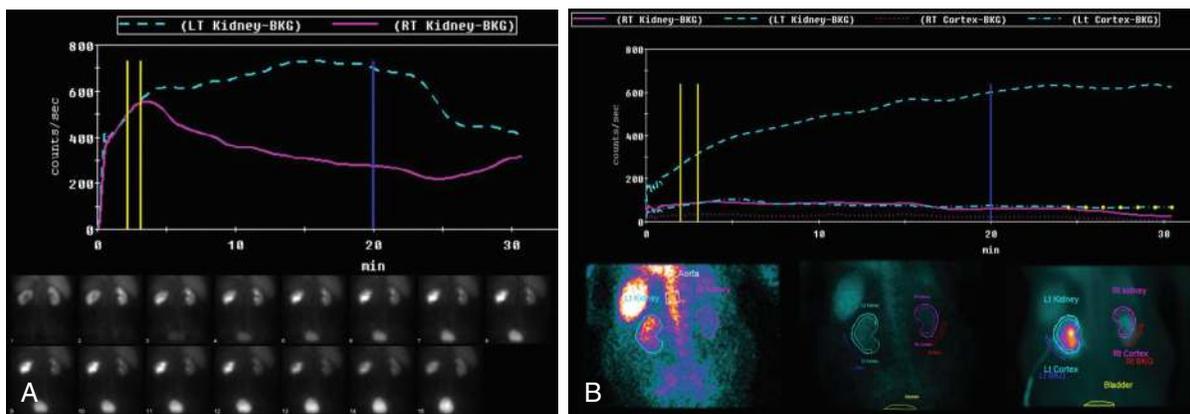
Isotope renography. A, ^{99m}Tc-mercaptoacetyltriglycine-renogram performed on a 54-year-old male with large benign intraabdominal mass causing radiographic unilateral ureteral obstruction. Note that radiotracer peak uptake (yellow vertical lines) is normal in the right kidney, whereas tracer uptake is delayed in the obstructed left kidney. Furosemide administration (blue vertical line) resulted in reversal of the partial functional obstruction. Time-sequence images of radiotracer uptake are shown. B, Mag-3 renogram of a 78-year-old male with stage 4 metastatic bladder cancer with retroperitoneal metastases and bilateral, chronic ureteral obstruction. Images obtained after bilateral percutaneous nephrostomy tubes revealed a marginally functioning left kidney and completely nonfunctional right kidney. Perfusion (lower left panel), $t = 0$ tracer uptake (lower middle panel), and time-averaged tracer uptake (lower right panel) images are shown.
